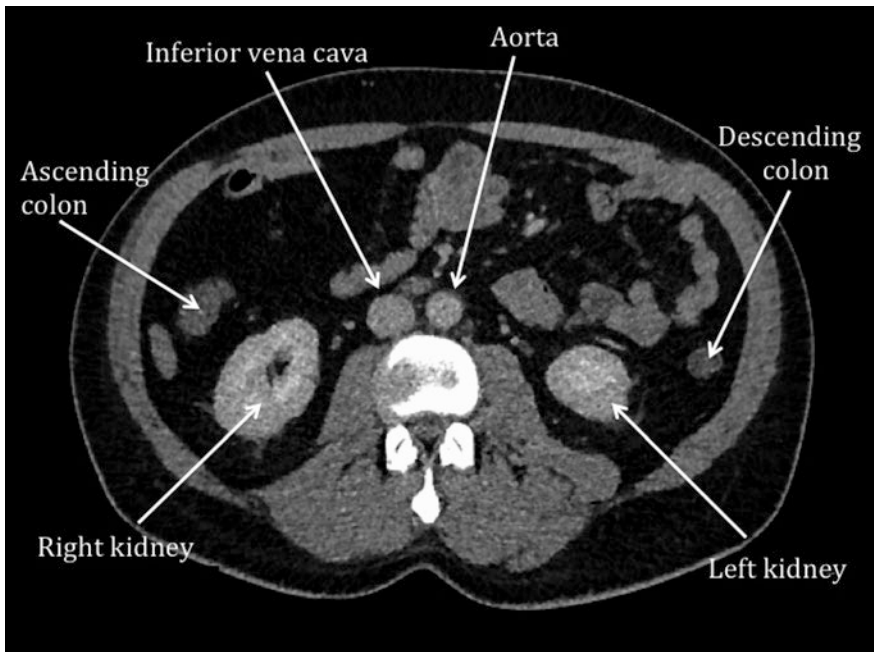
Axial slice from contrast-enhanced CT abdomen/pelvis demonstrating normal anatomy
